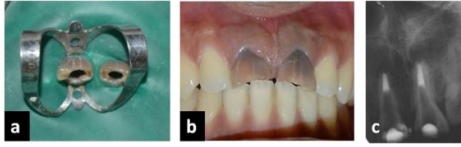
Clinical pre operative photographs of maxillary incisors, Fig 1b: Pre operative diagnostic radiograph
